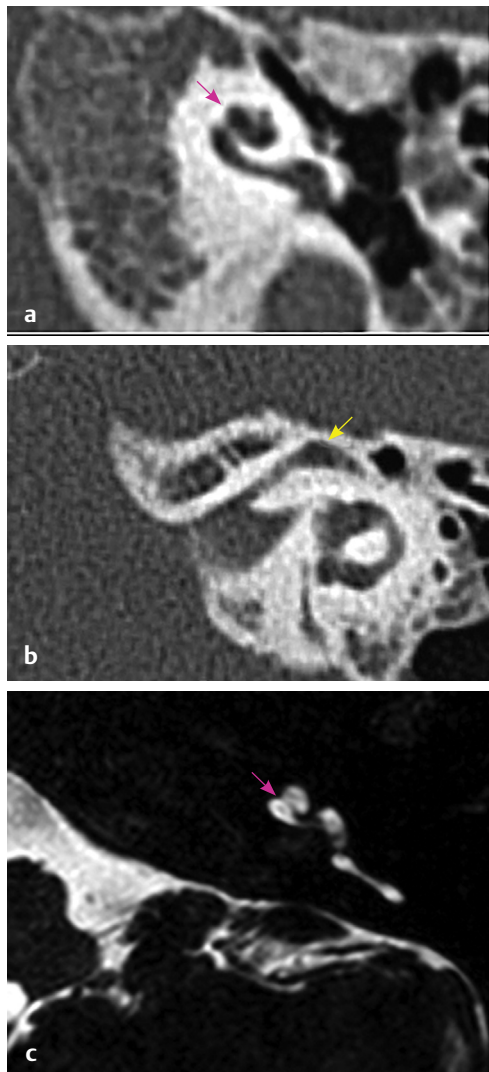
(a, b) HRCT temporal bone, bone window, axial section shows and facial nerve (yellow arrow) is seen running an abnormal course in labyrinthine segment. (c) MRI CISS sequence, axial sections show CH4 in which cochlea (pink arrow) has hypoplastic and anteriorly placed middle and apical turns with normal basal turn and an anteriorly placed facial nerve.
